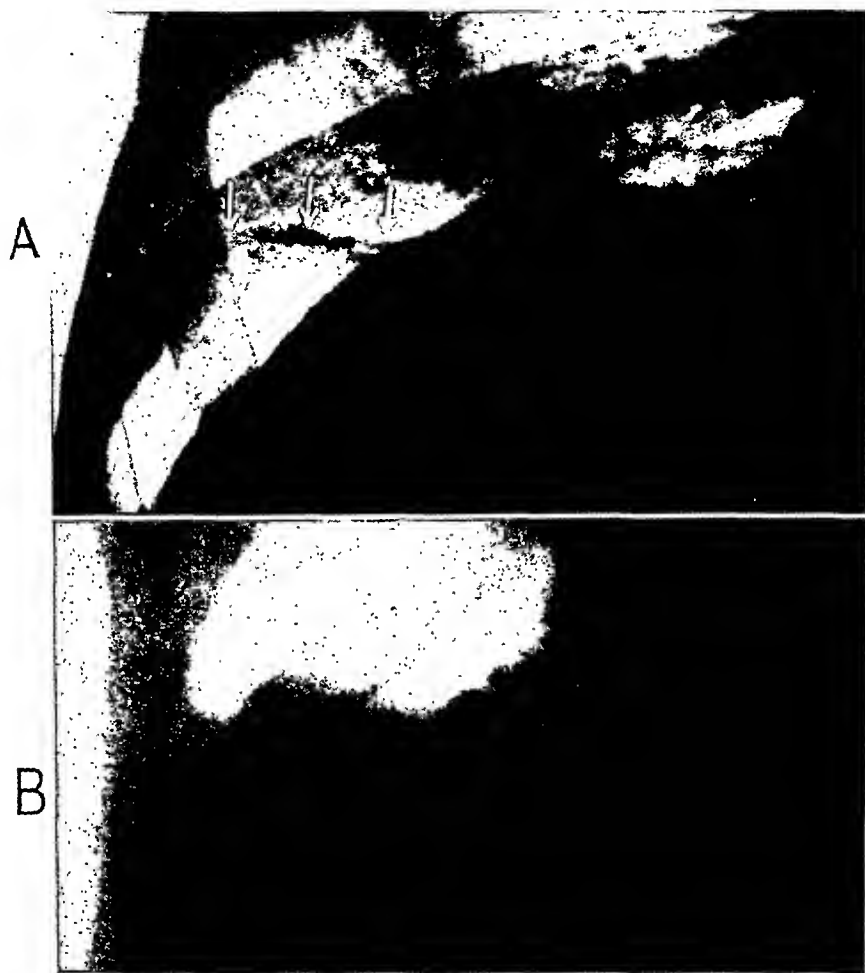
Fifteen minutes after a fall, a disk-like atelectasis is seen in the right lower lobe (arrows); the fractured rib is not included in the roentgenograph (A). The right base shows pneumonic infiltration 20 hours later (B). See text.
